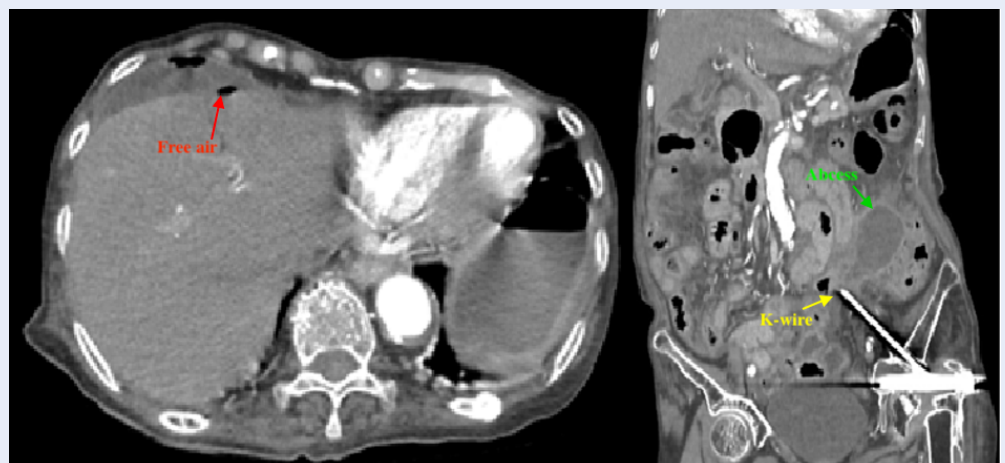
Abdominal computed tomography scan shows free air in the abdomen (red arrow), an abscess in the left iliac fossa (green arrow), and the K-wire penetrating into the pelvic adjacent to the abscess (yellow arrow).
